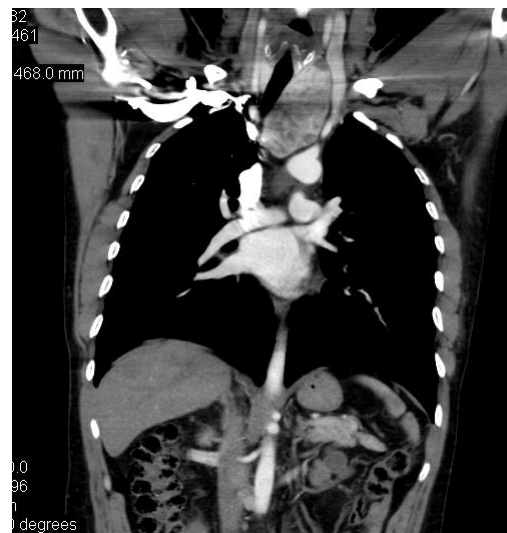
CT scan showing a thyroid mass displacing the trachea, with intra-thoracic extension
